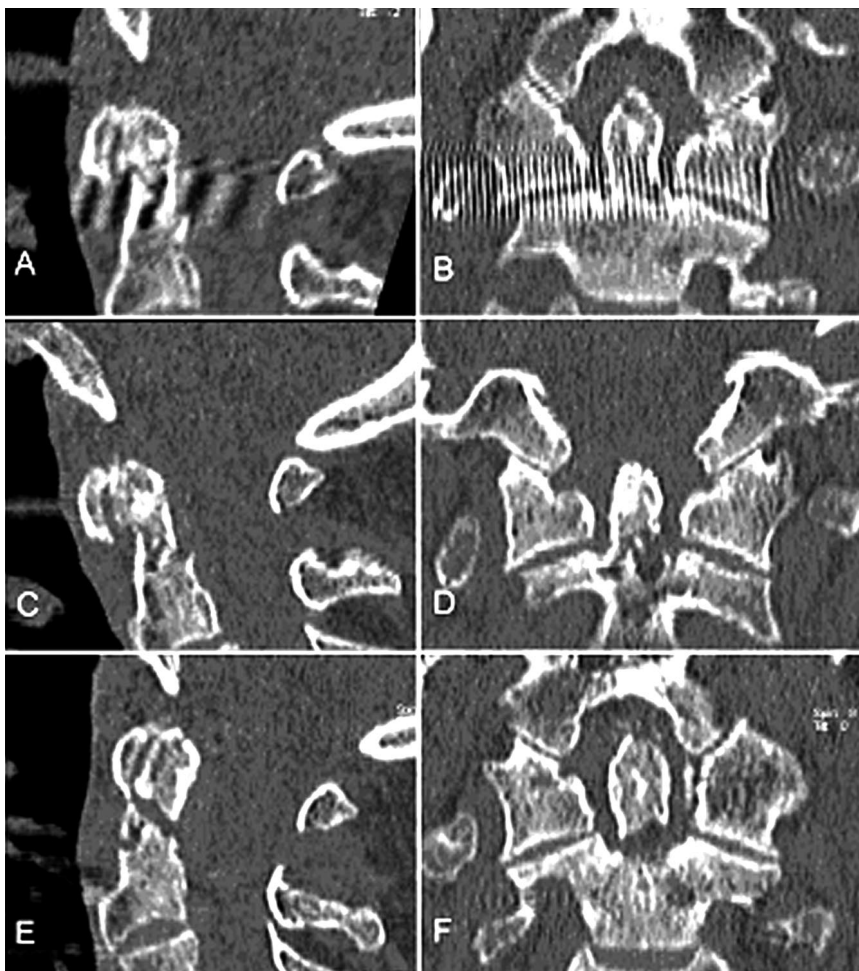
Computer-tomographic documentation of the same fracture: Preoperative radiograph, sagittal (A) and coronary (B), follow-up radiographs after 8 weeks (C,D) and 12 weeks (E,F). An increase in osteolyses in the fracture zone is clearly visible after 12 weeks.
